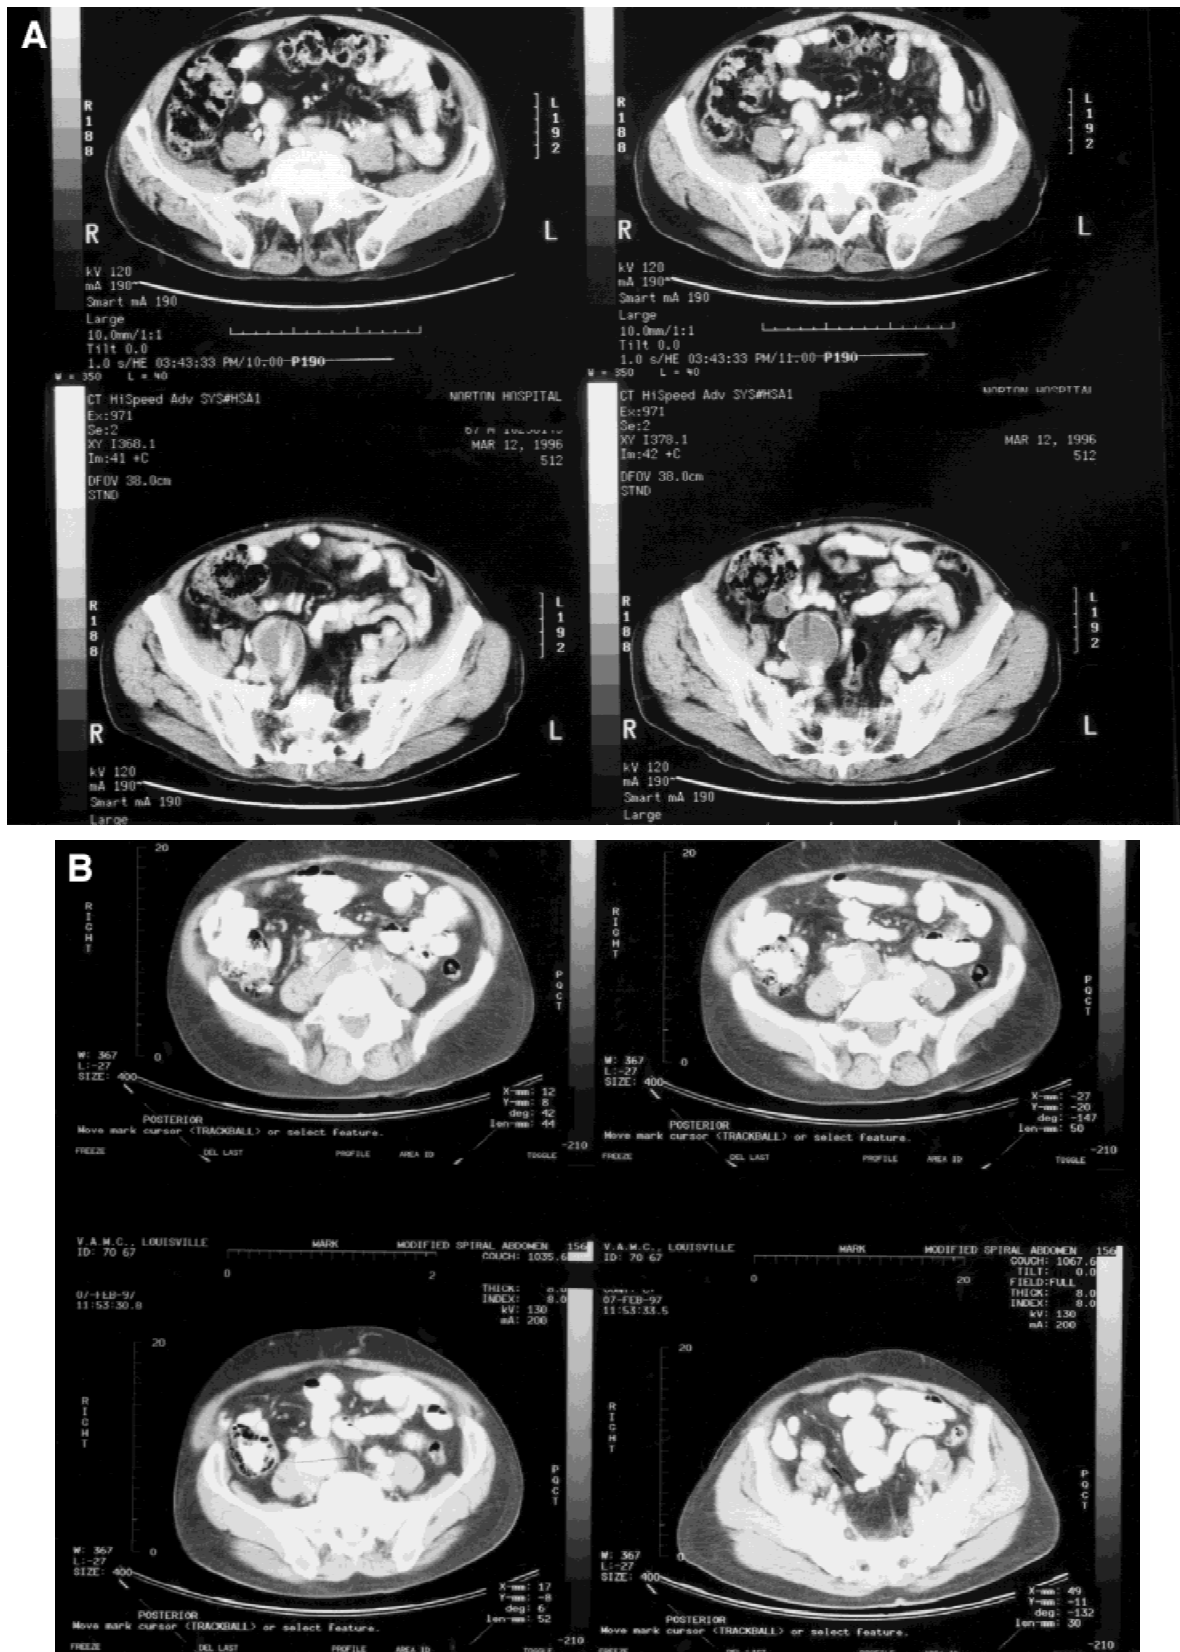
Isolated common iliac artery aneurysms diagnosed by CT in an asymptomatic patient (A). Extremity swelling caused vein compression in a patient with a common iliac artery anastomotic pseudoaneurysm years after aortobi-iliac bypass repair of an abdominal aortic aneurysm (B).
